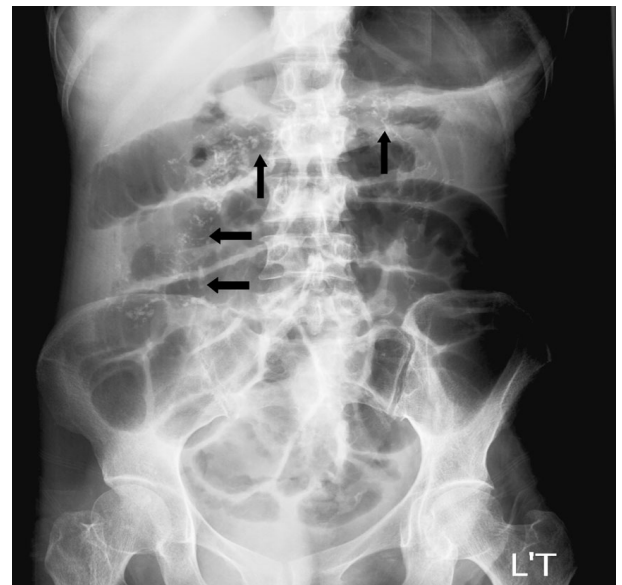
Plain abdominal radiograph shows multiple tortuous threadlike calcifications (arrows) in the region of the right side of the colon, transverse colon and left side of the colon. Dilated bowels are noted, suggesting ileus.
